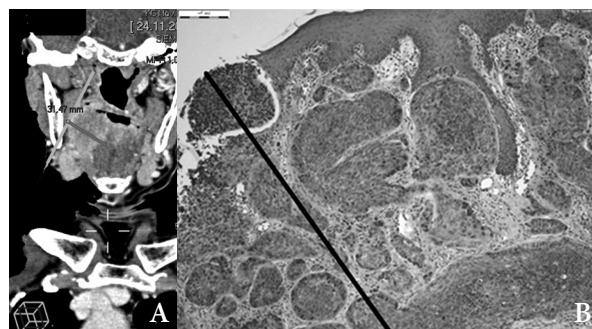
Determination of TT in OSCC by CT (A) and HP measurements (B)
